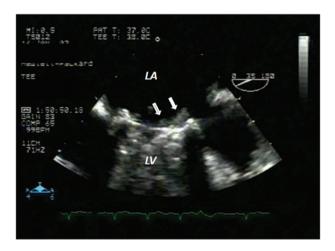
A 35-year-old woman presented with acute pulmonary oedema and was operated urgently. Transoesophageal echocardiogram showing a large obstructive thrombus (arrows) visualized as a soft mass on the atrial surface of a single tilting disc mitral prosthesis.
